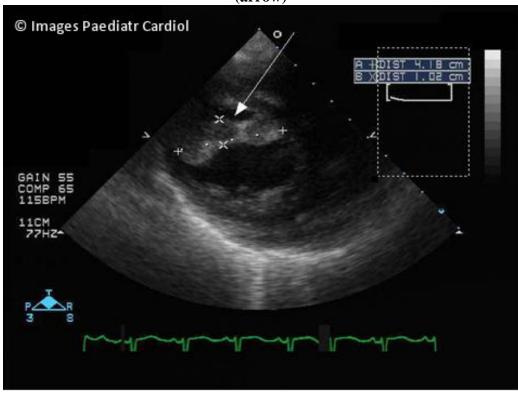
Four-chamber view, 2D echocardiogram showing a large non-mobile thrombus in the LV apex (arrow)
